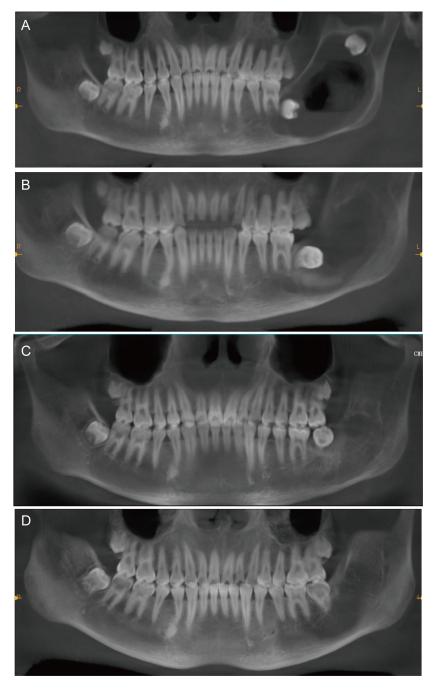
Reconstructed CBCT images in different periods. (A) Preoperative reconstructed CT images of the mandibular lesion. (B) Reconstructed CT images of the mandibular lesion three months after the decompression. (C) Reconstructed CT images of the mandibular lesion ten months after the decompression (before the secondary enucleation). (D) Reconstructed CT images of the mandibular lesion eighteen months after the enucleation.
